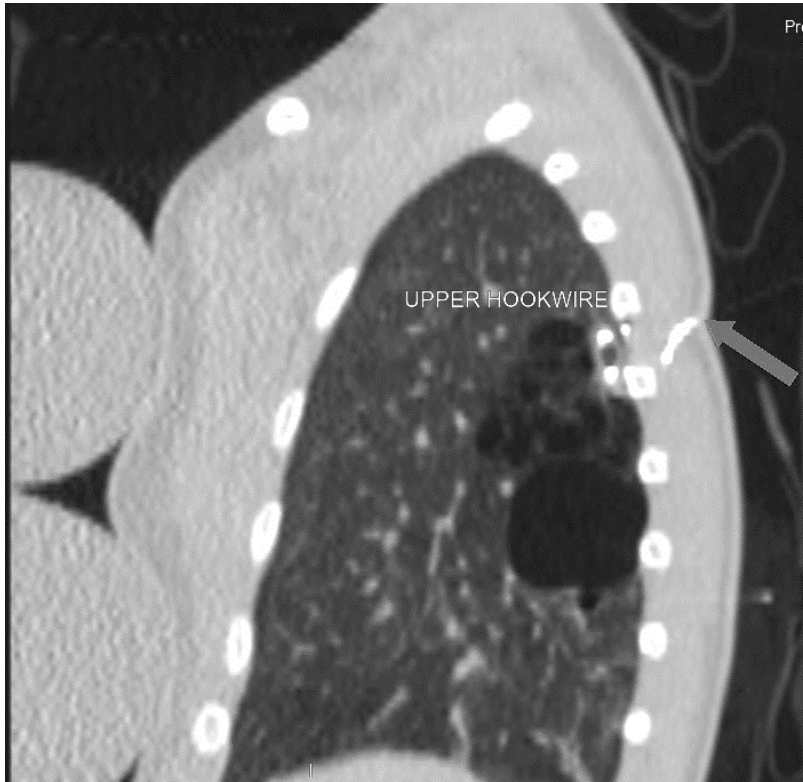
Sagittal view CT image with arrow pointing to the superior hookwire.
